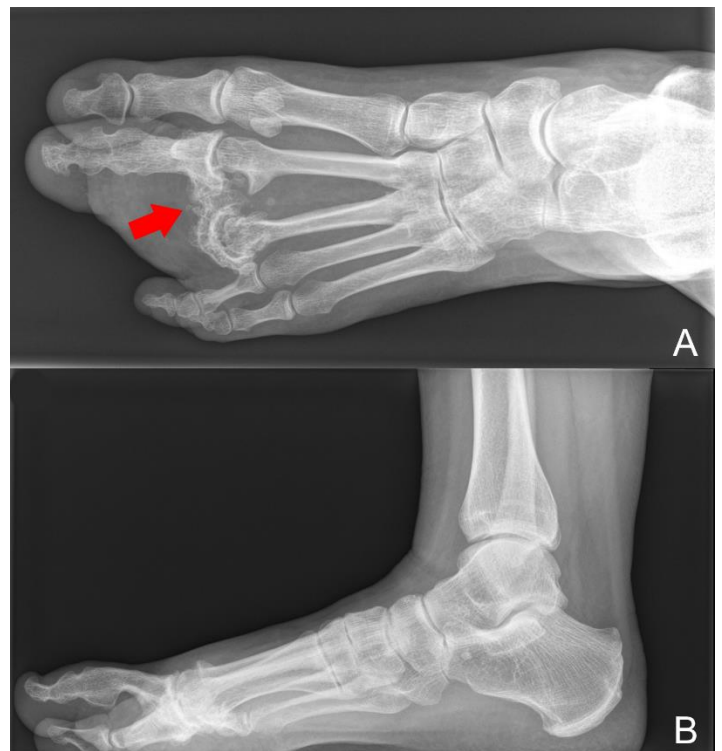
Conventional radiographs of the left foot of case 3. 7A: A-P radiograph showing bone exostosis and osteoarthritic deformed bones of the second and third toe (arrow). 7B: lateral radiograph showing elevation of the second toe because of the plantar swelling.
